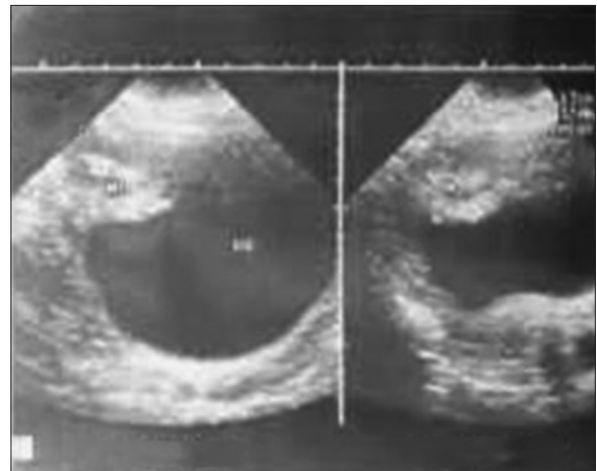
Ultrasonography showing mass protruding into the bladder lumen along anterior bladder wall
